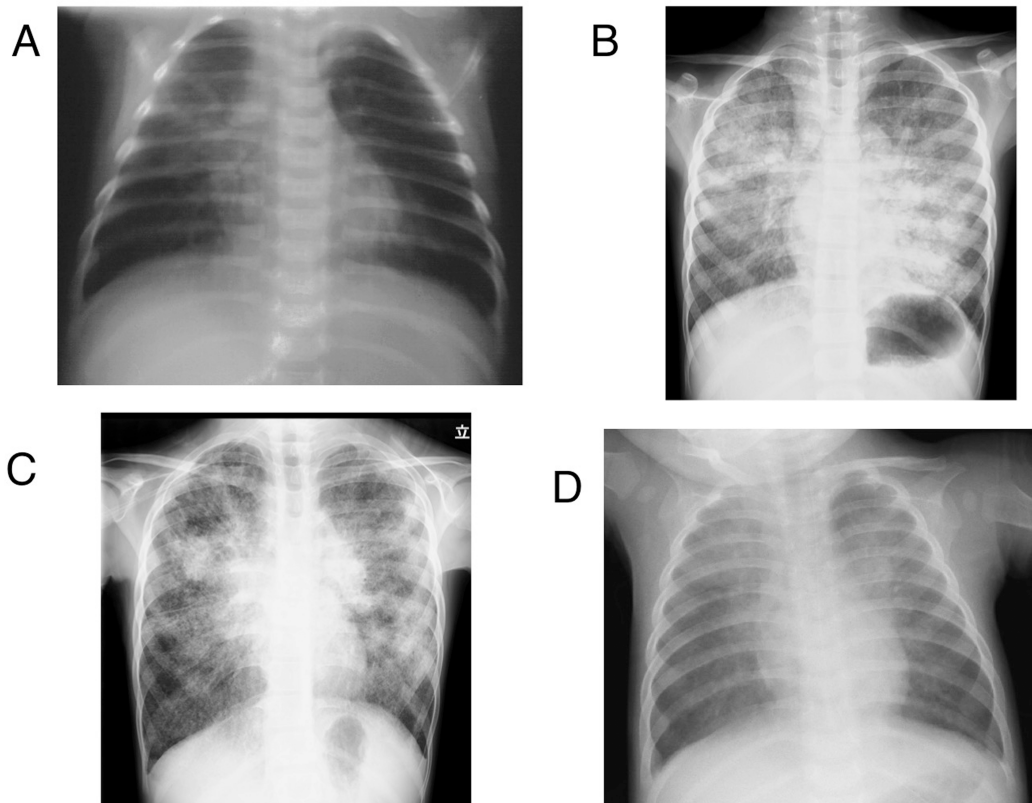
Chest X-ray findings
